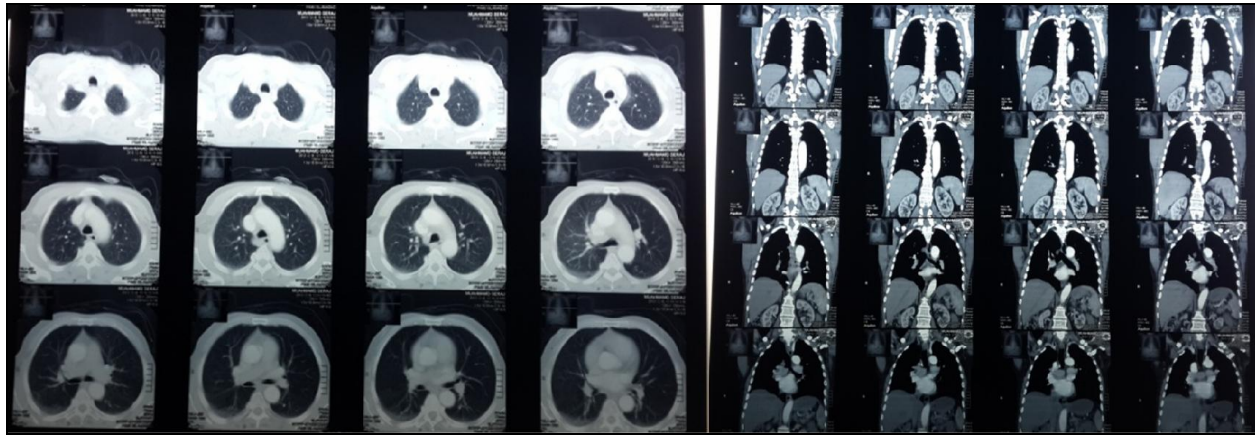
CT scan showing soft tissue mass in left lower chest
